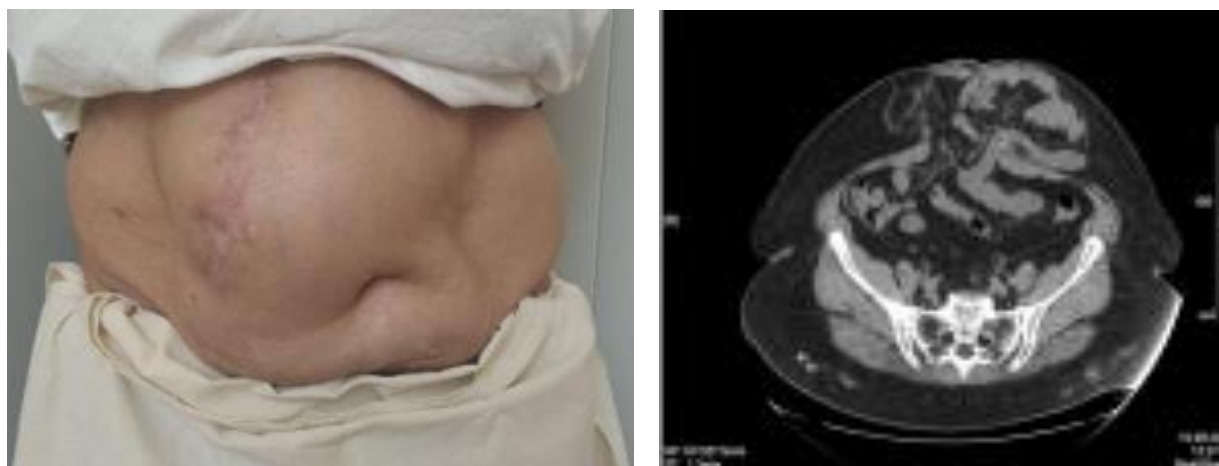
Patient P., 56 years old with postoperative ventral hernia (M²W³R⁰) and computed tomography of the anterior abdominal wall and abdominal cavity
